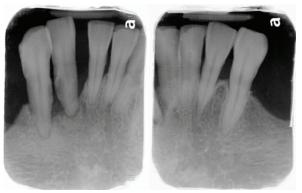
Pre-treatment periapical films.
